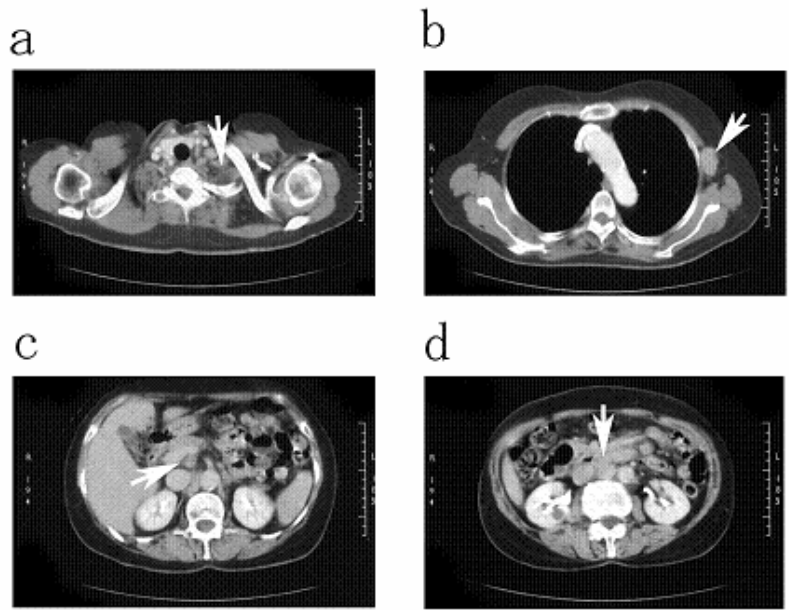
CT images show lymph nodes swelling in; a: left cervical lymph nodes. b: the left axillary lymph node. c: the retropancreatic lymph node. d: para-aortic lymph nodes.
